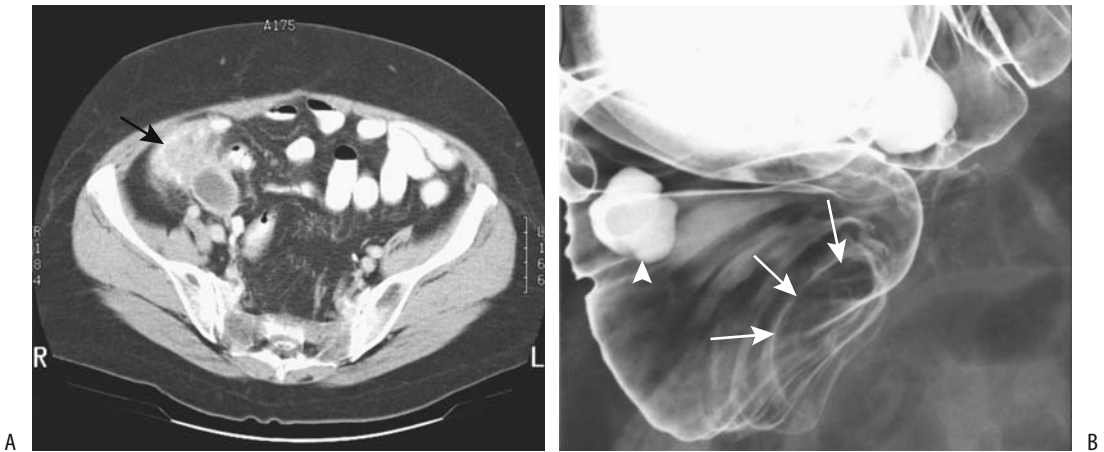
Appendicitis associated with a cecal carcinoma. A: Computed tomography (CT) identifies a soft tissue tumor indenting the cecal lumen (arrow). The fluid-filled structure adjacent to the tumor was believed to represent an appendiceal mucocele. A barium enema outlined a cecal carcinoma, confirmed by resection. (Courtesy of Patrick Fultz, M.D., University of Rochester.) B: Barium enema in another patient reveals a tumor at the cecal tip (arrows) and an incidental cecal diverticulum (arrowhead). An appendiceal phlegmon or abscess can have a similar appearance.
